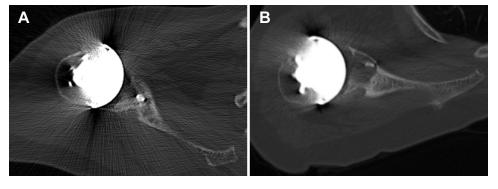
CT scan evaluation of a 69-year-old female patient assessed at a short- and mid-term time point after anatomic total shoulder arthroplasty of the right shoulder. At 24 months postoperatively, no signs of loosening and a well osseointegrated central peg are seen (A). Over time, the initial well-integrated central peg demonstrated radiographic signs of loosening with osteolytic areas and progressive radiolucencies around all pegs, as seen on CT scan at 94 months of follow-up (B). *CT*, computed tomography.
